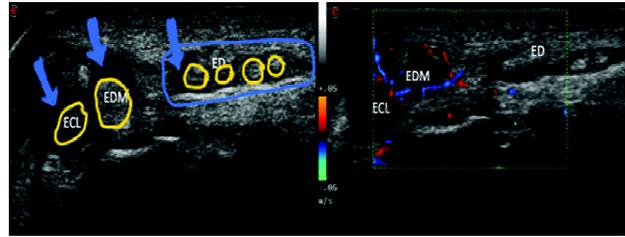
Sonographic image on axial section (on the left) showing fluid (blue arrows) and vascularity (on the right) along extensor group of tendons (yellow circles).
